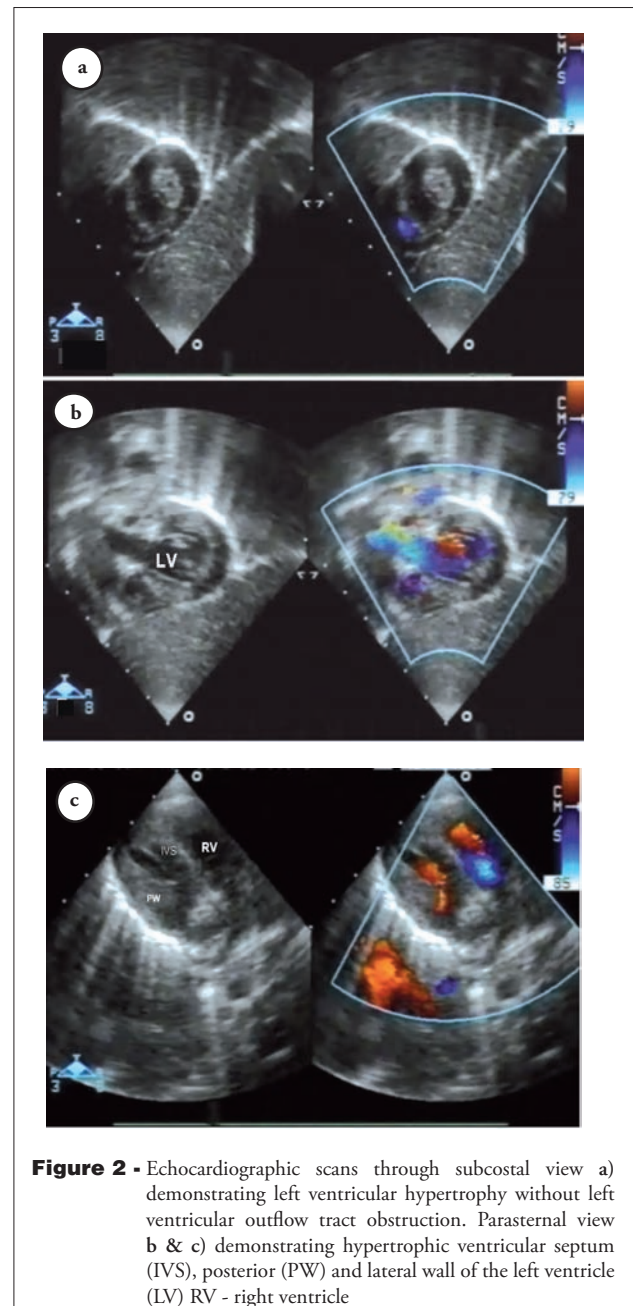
Echocardiographic scans through subcostal view a) demonstrating left ventricular hypertrophy without left ventricular outflow tract obstruction. Parasternal view b & c) demonstrating hypertrophic ventricular septum (IVS), posterior (PW) and lateral wall of the left ventricle (LV) RV - right ventricle
